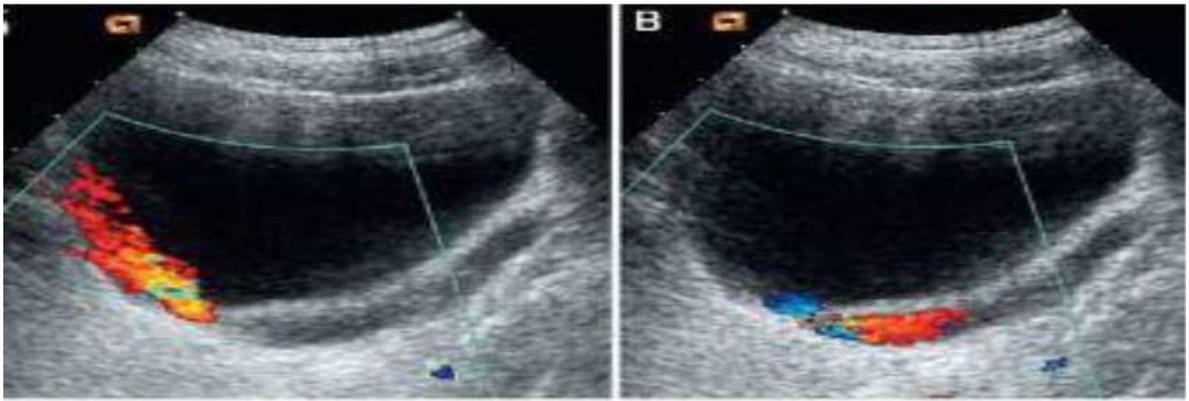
Dopplerographic picture of patient L.G. I.b. 122/03 with refluxing megaureter III degree
